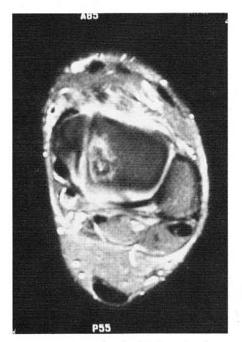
MRI study of axial view showing a Stage II/III posterior medial lesion.
